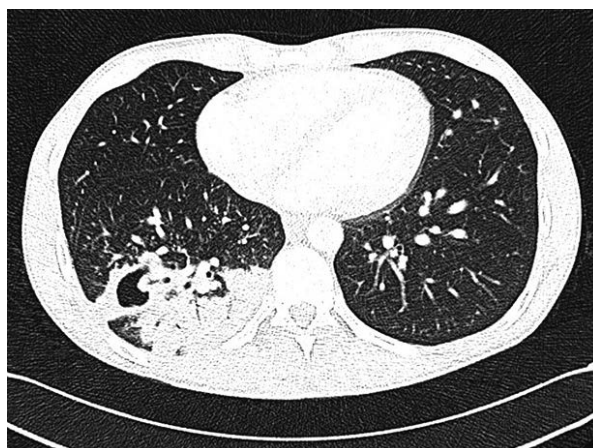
Chest CT. Cavities in the lower right lobe
